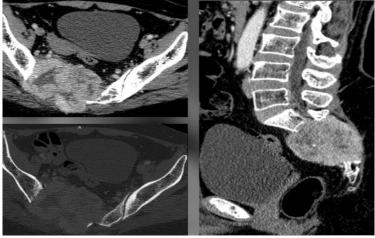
Contrast-enhanced CT scan of the lumbosacral spine
